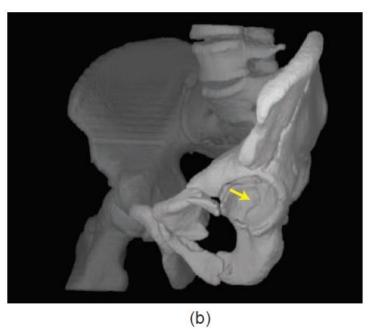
(a) On a sagittal reformatted CT image, an anteroposterior course of an acetabular fracture is visible. (b) A 3D view on the acetabular surface more clearly localizes the transtectal course of the fracture extending into the posterior column. (Courtesy of Professor M. H. Smet, Department of Radiology, and Professor J. Van Cleynenbreugel, Lab. Medical Image Computing.)
